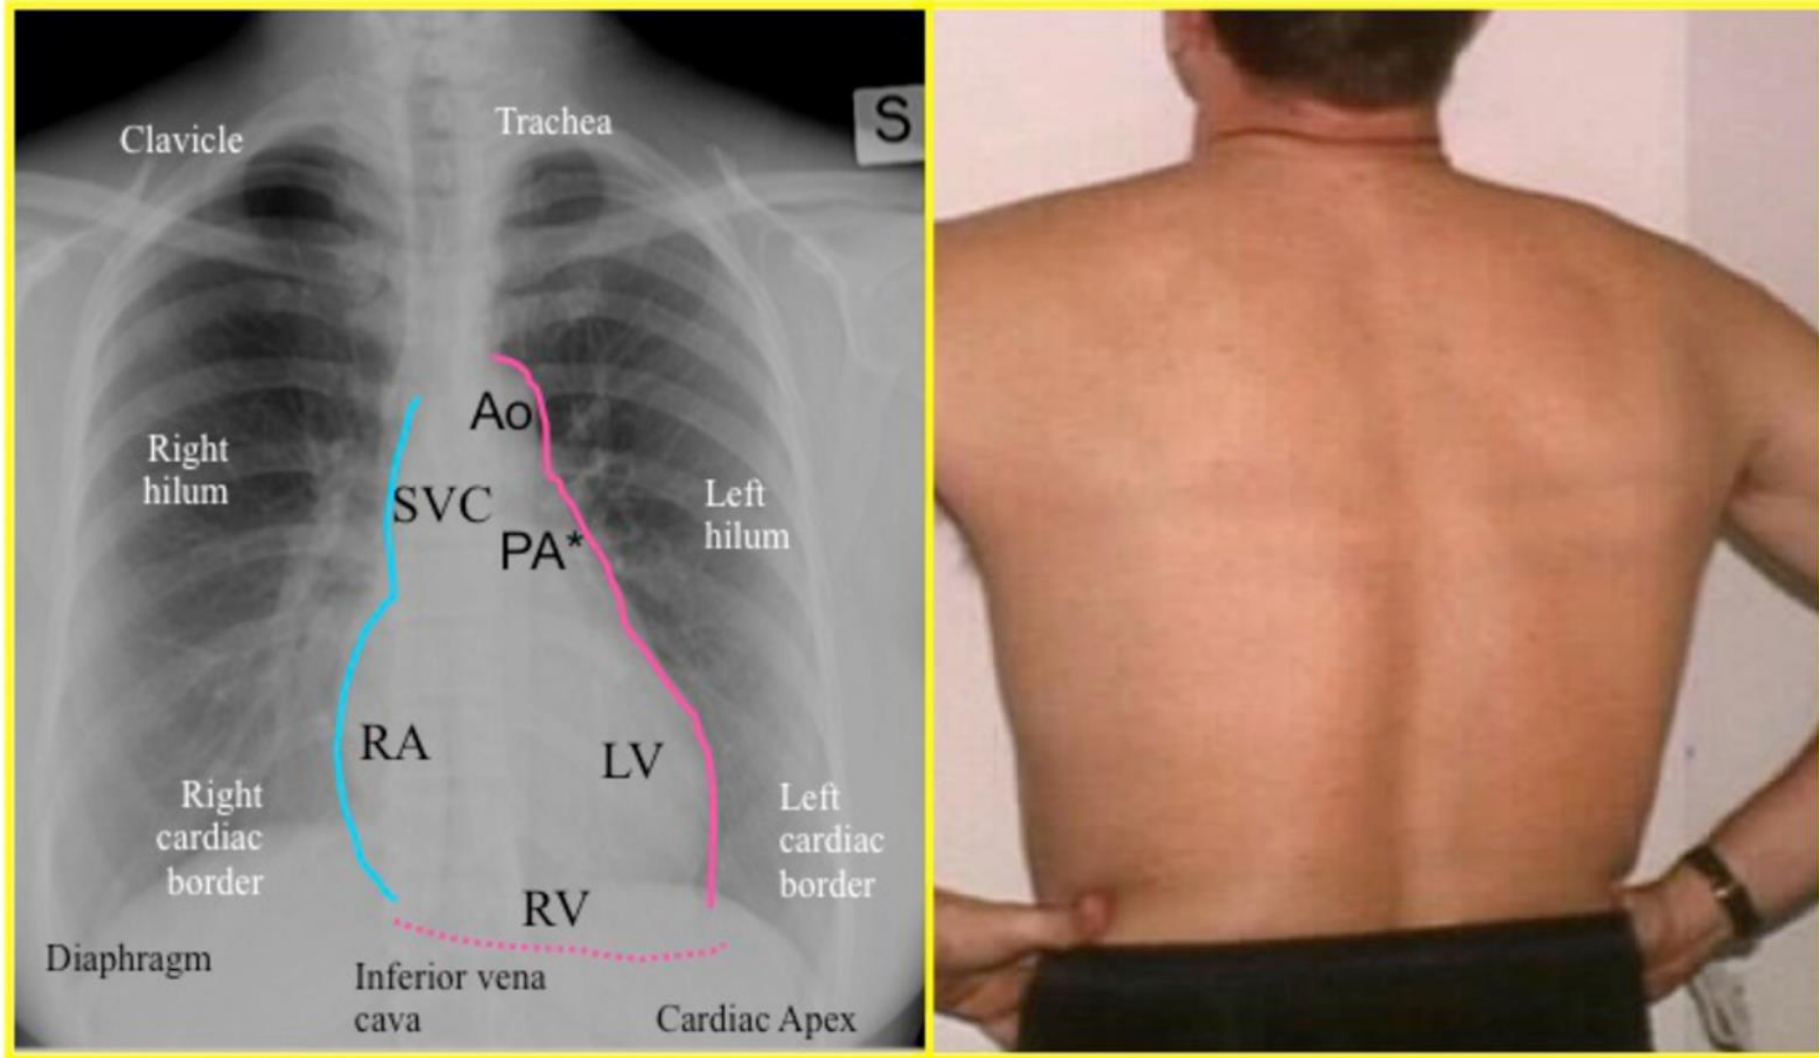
Cardiac borders on a Posterior-Anterior (P-A) chest radiograph (CXR). Relationship between borders of the cardiac shadow and the adjacent lung portion. Ao=aorta arch; SVC=superior vena cava; PA=pulmonary artery; RA=right atrium; LV=left ventricle; RV=right ventricle.
